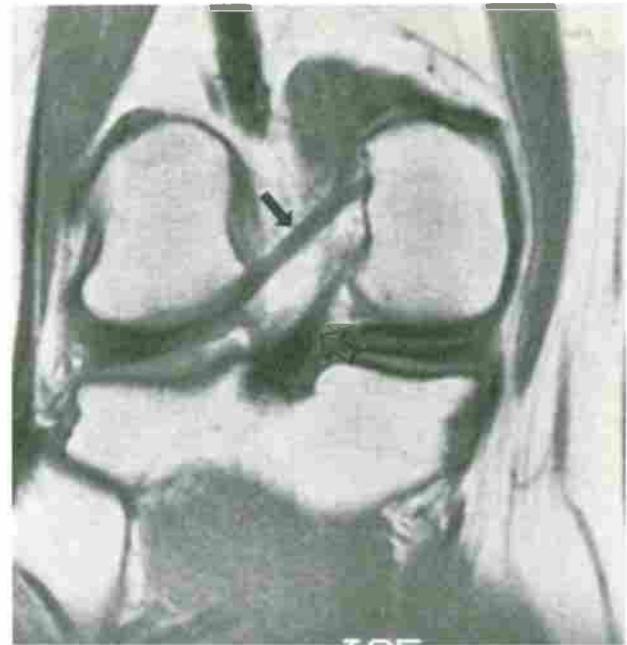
Meniscofemoral ligaments. Coronal T1-weighted (TR/TE, 800/20) image demonstrates the ligament of Wrisberg (solid arrow) extending from the posterior horn of the lateral meniscus to the medial femoral condyle. Note the proximal segment of the posterior cruciate ligament (open arrow) coursing vertically.
